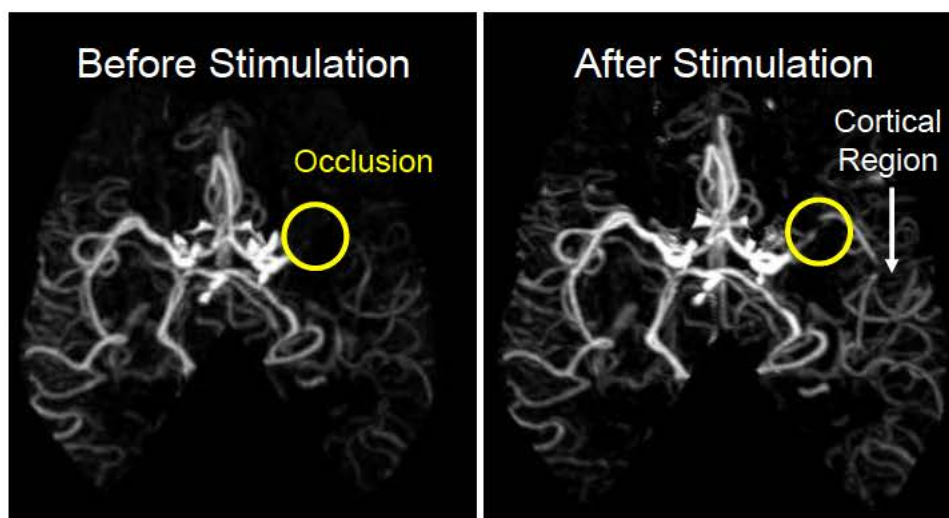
CT Angiography of a CCI Patient Before and After SPG Stimulation
